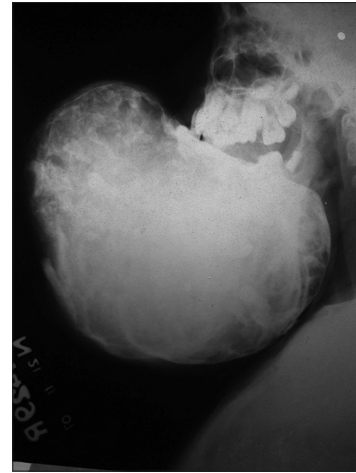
Lateral X-ray of the child showing extent and ossifying nature of tumor
